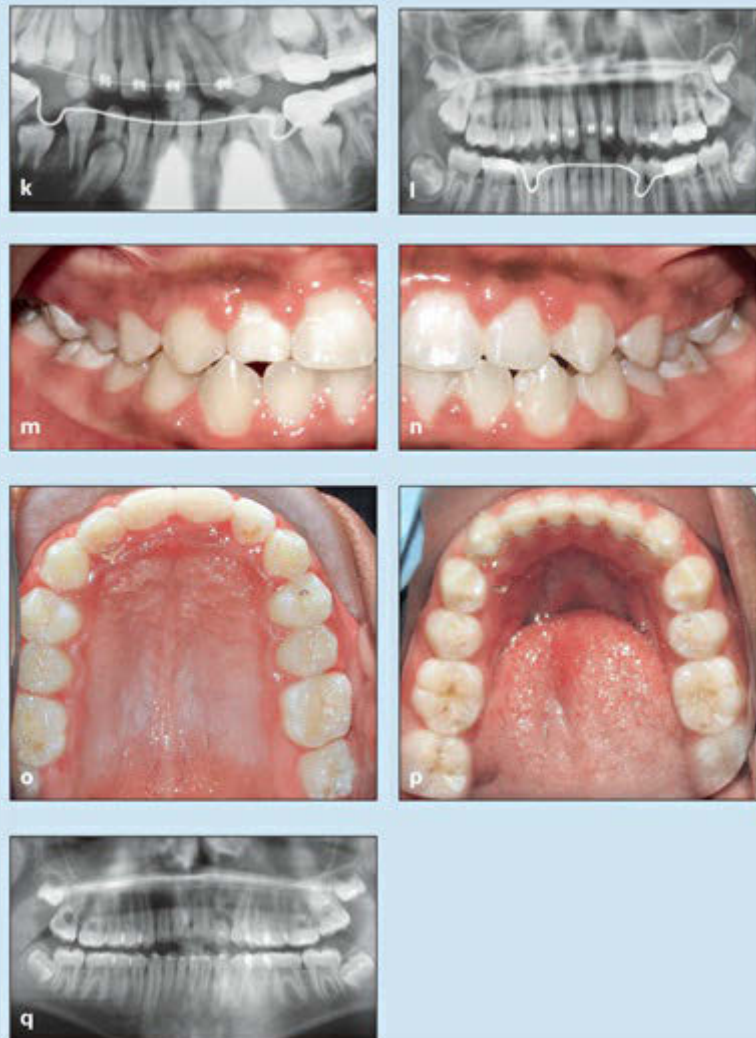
(cont) (k and l) Guidance of eruption. (m to p) Posttreatment occlusion. (q) Posttreatment panoramic radiograph.
